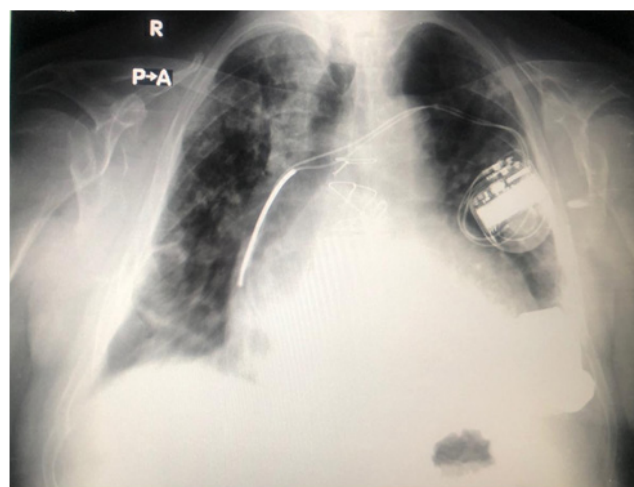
Chest X-Ray film with diffuse ground glass opacities.
